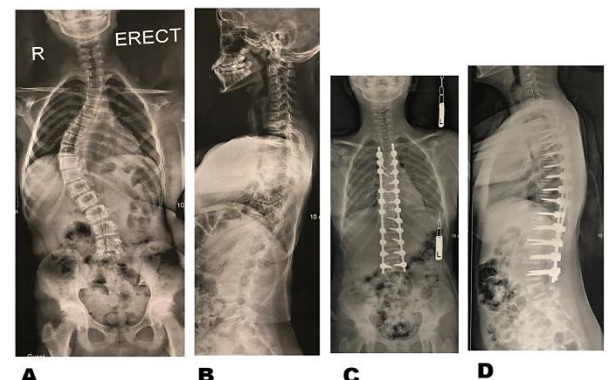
A 13-year-old girl with Lenke type 1 curve undergoing T4-L5 posterior spinal fusion; A, B preoperative standing full length posteroanterior and lateral radiographs; C, D after deformity correction and instrumentation
